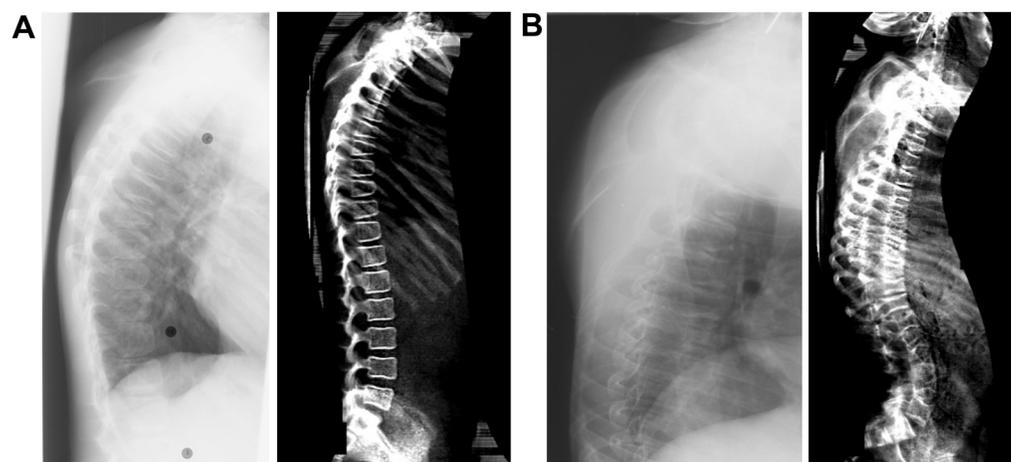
Radiographs (left side) and iDXA pictures (right side) of the lateral spine of 2 individual patients. (A) A pair of images (radiograph and iDXA) which are eligible to perform the measurements. (B) An ineligible pair of images. In both patients, the quality of pictures seems to be comparable between the radiograph and the iDXA scan.
